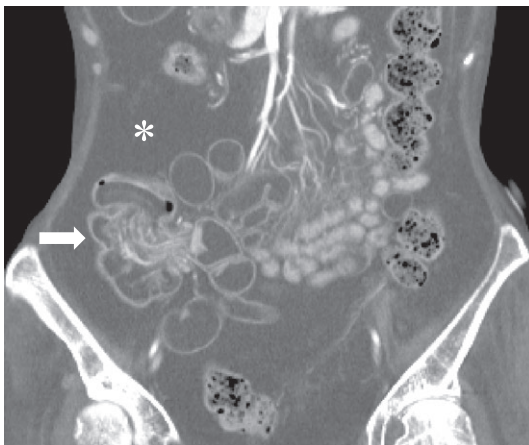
Contrast-enhanced CT image. Ileo-colonic intussusception is seen (arrow)
